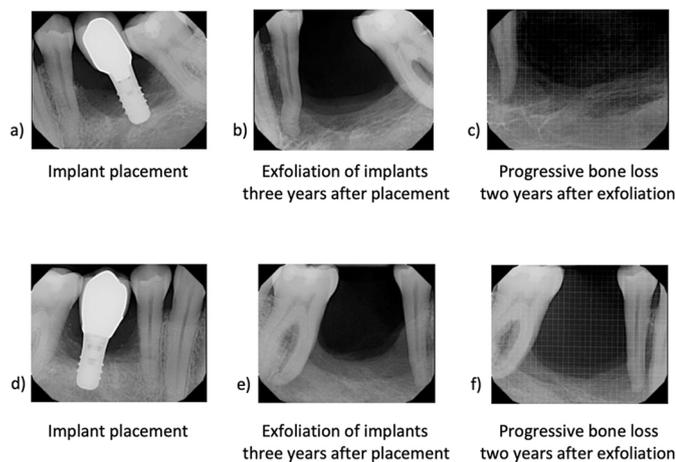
Periapical radiographs of implant site and exfoliation. (a) Implant placement, (b) exfoliation three years later, and (c) progression of bone loss two years after implant exfoliation at the site of the left mandibular second premolar. (d) Implant placement, (e) exfoliation three years later, and (f) progression of bone loss two years after implant exfoliation at the site of the right mandibular first molar.
